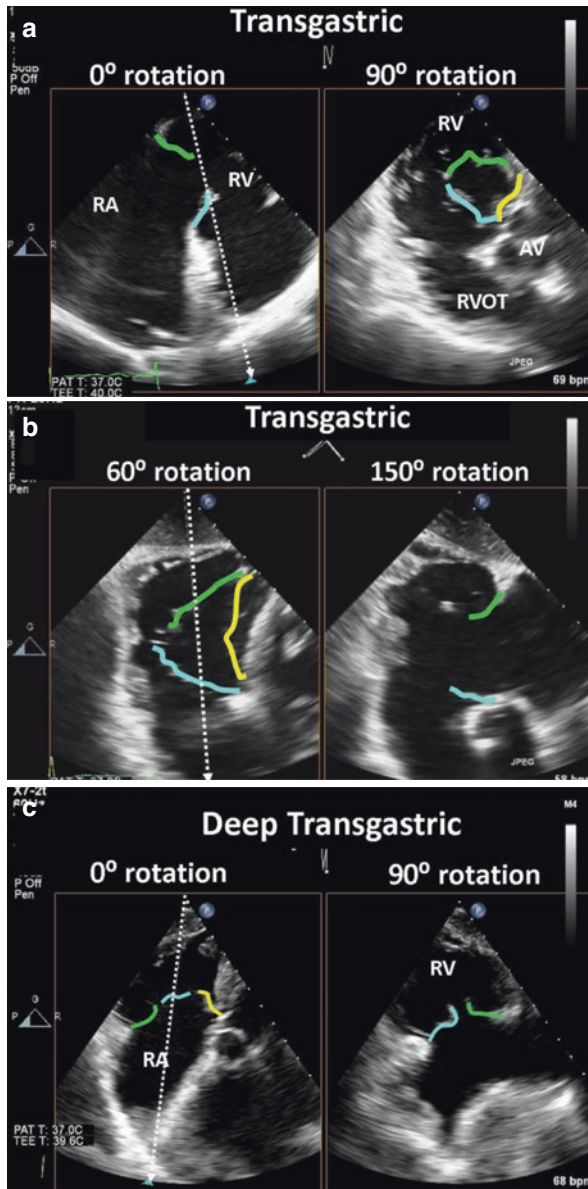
Simultaneous biplane imaging from transgastric views with right and antelexion, the inflow-outflow view of the right heart (panel a) images the anterior (blue line) and posterior leaflet (green line) at 0 degrees. The orthogonal view shows all three tricuspid valve leaflets. This short-axis view of the tricuspid valve can also be imaged between 60 and 90 degrees (panel b) with the simultaneous multiplane imaging plane used to image all three leaflet tips. Deep transgastric views of the tricuspid valve (panel c), may align the insonation beam with the flow across the tricuspid valve for Doppler assessment
